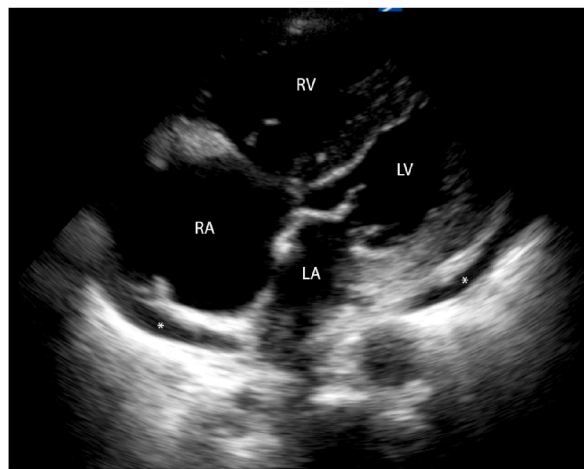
Apical four-chamber view of the heart on point of care ultrasound on ICU admission. Severely dilated RA and RV, and a small pericardial effusion were seen. The RA appears to bulge into the LA. No air bubbles were visualized in the chambers. RA, right atrium; RV, right ventricle; LA, left atrium; LV, left ventricle; *, small pericardial effusion.
